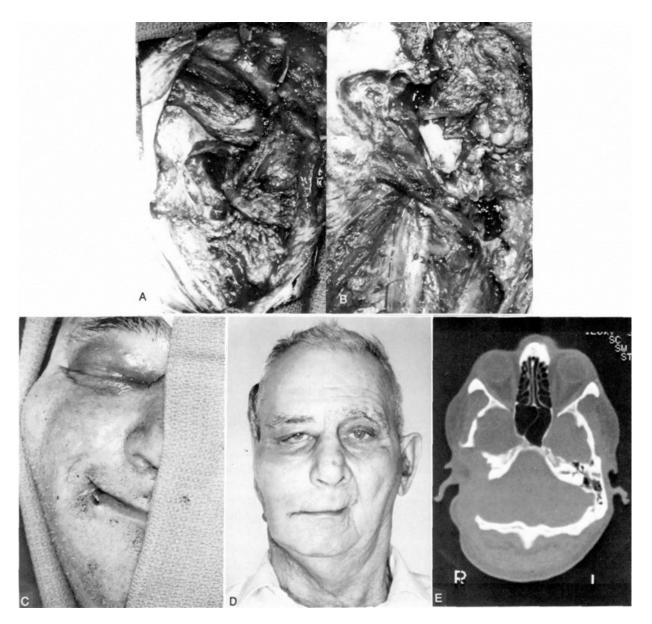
Radical temporal bone resection with superficial parotidectomy, partial mandibulectomy, and radical neck dissection for squamous cell carcinoma invading deeply into the temporal bone. A, Post-resection retroposition of the parotid gland and preparing the dual temporalis flap. B, Obliteration of the petrous apex, middle ear, and mastoid with the posterior temporalis muscle, and the use of the middle portion of the muscle to reanimate the face. C, Reanimation of the eyelids and the lips with dynamic temporalis slings. The defect was closed with a latissimus dorsi myocutaneous flap. D, The patient at 3 years NED followup. E, CT demonstrates surgical defect.
